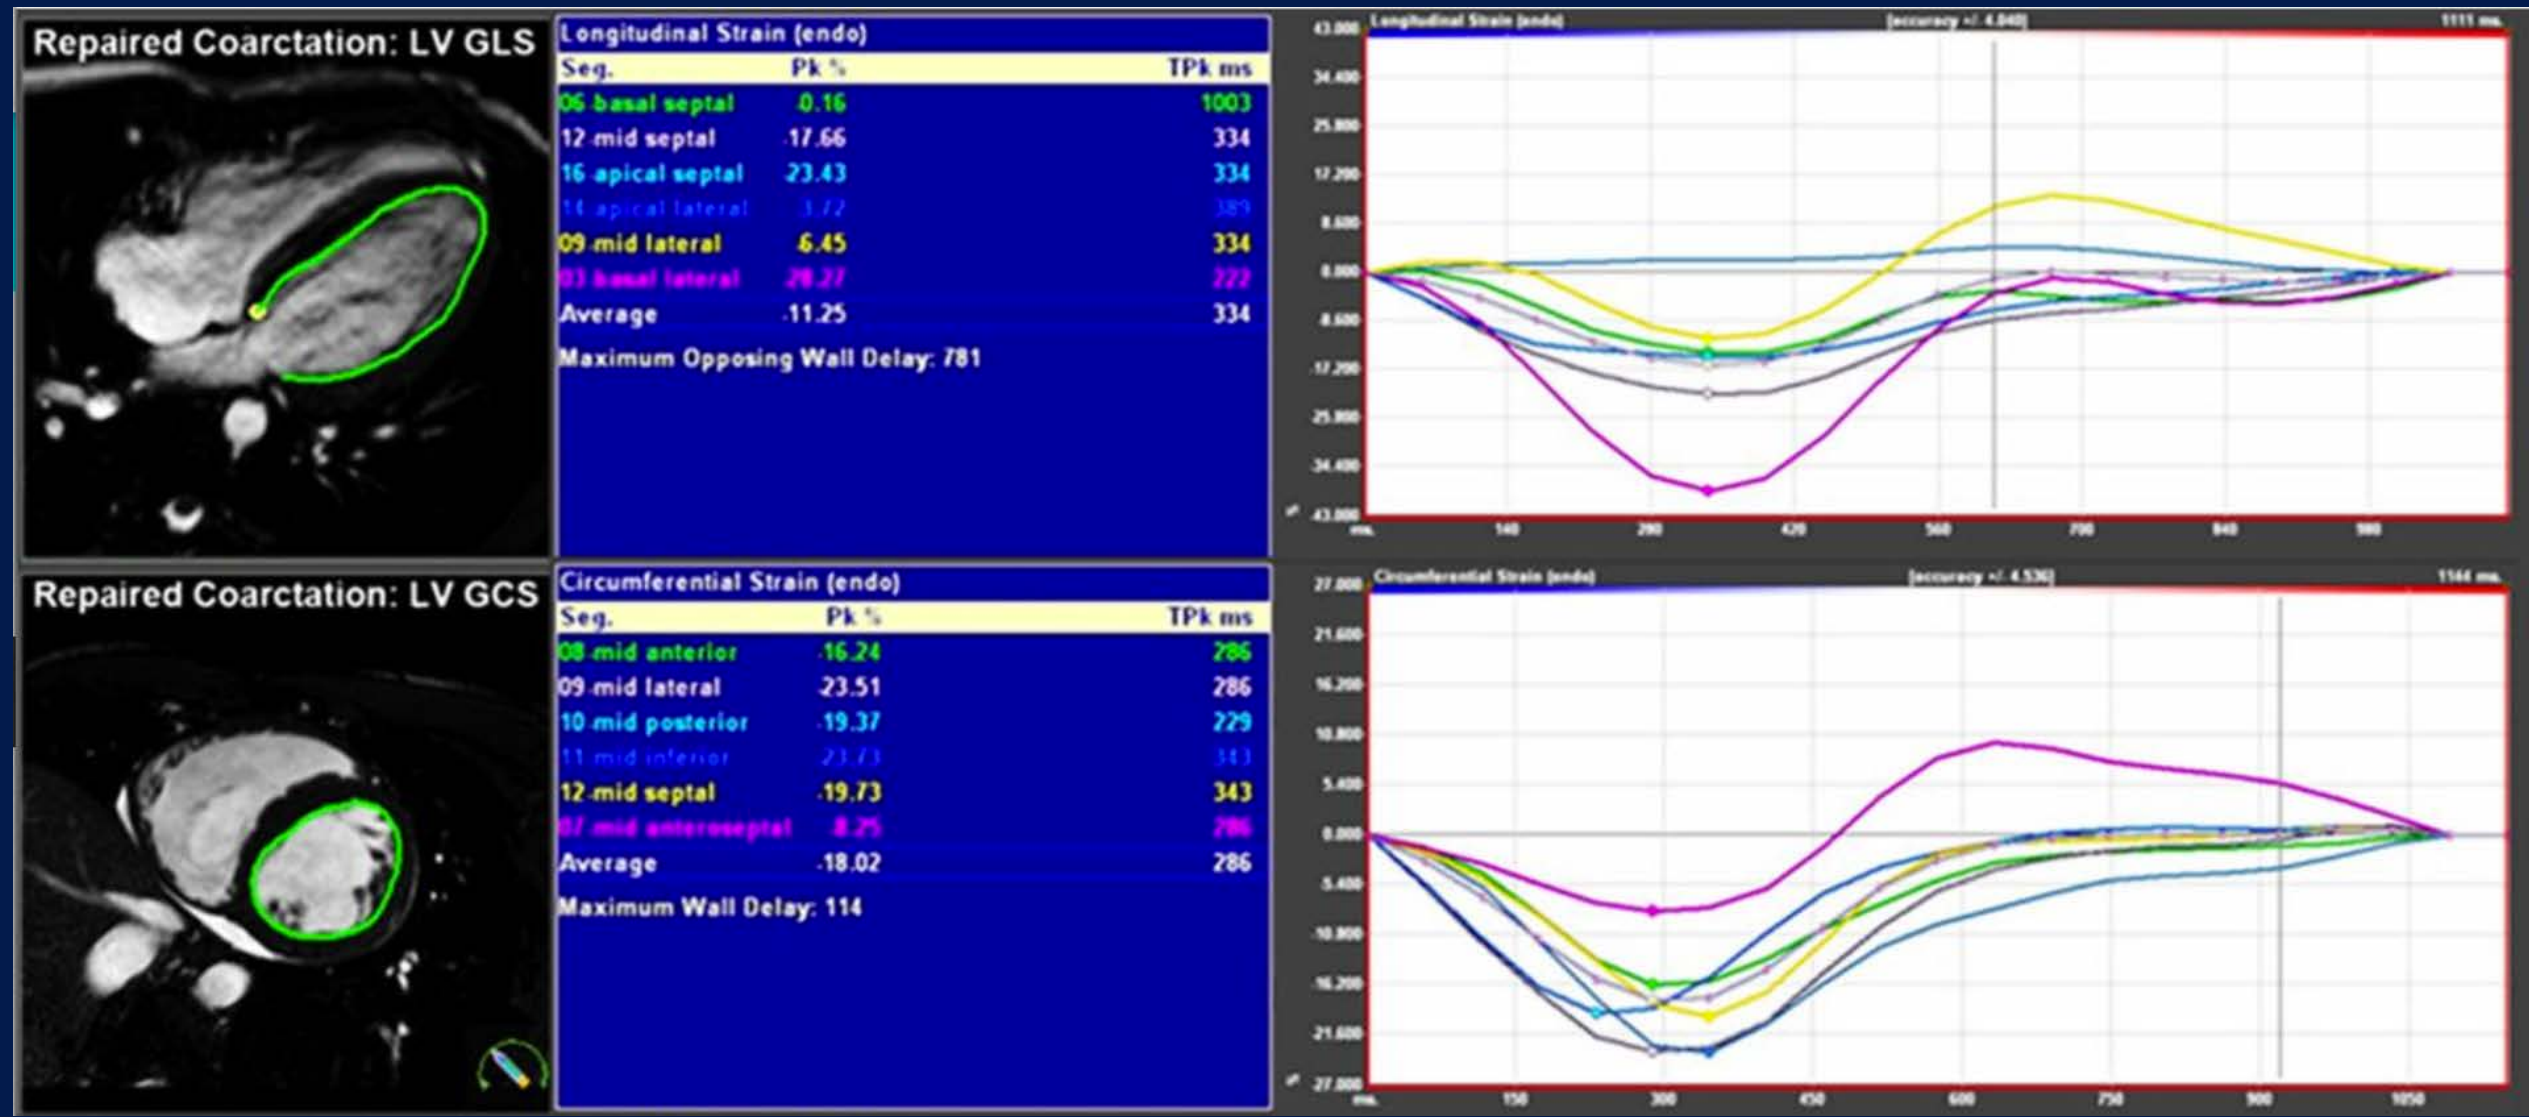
Circumferential Strain Assessment Using Feature Tracking Cardiac MRI imaging
